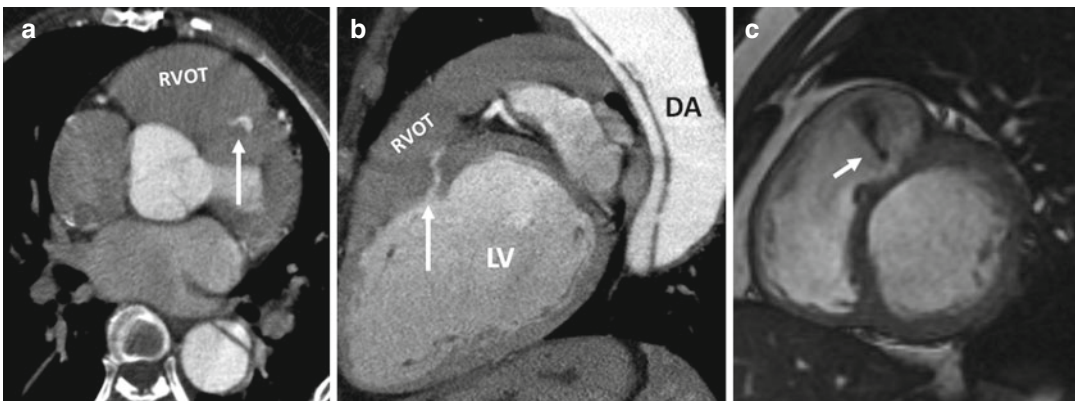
(a, b) Axial and long axis CT images show that a small infundibular muscular ventricular septal defect (*arrows*) was incidentally found in this patient who admitted for treatment of descending thoracic aortic (*DA*)
